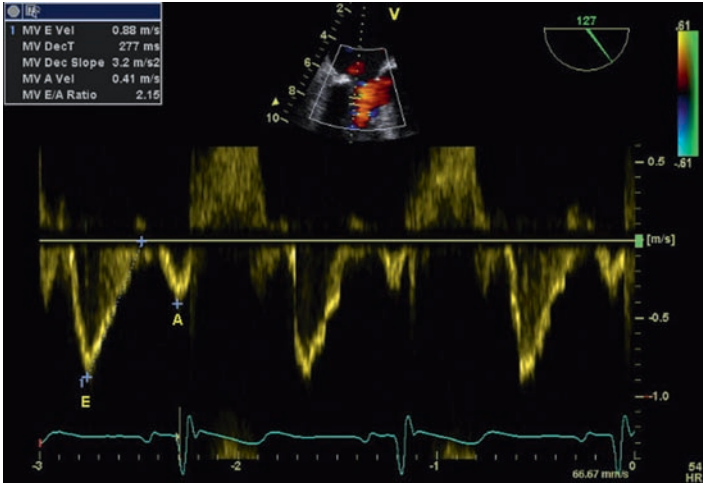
Pulse wave Doppler recording of the mitral inflow taken from the mid esophageal long axis view demonstrating the measurement of the peak E wave velocity, peak A wave velocity and the E wave deceleration time.
